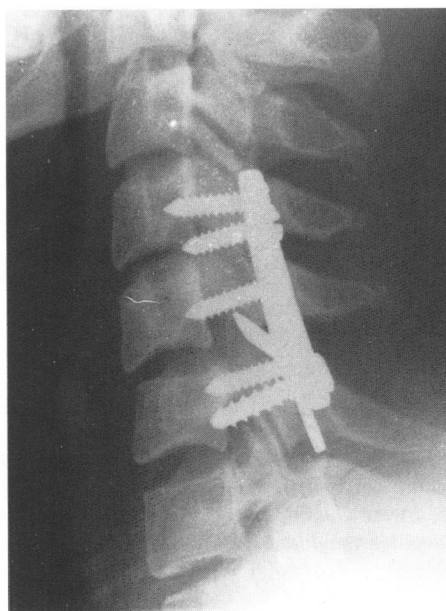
5.5 year postoperative lateral radiograph management of a fractured articular pillar by posterior fusion and Roy-Camille plates. The kyphotic deformity was not completely corrected.
